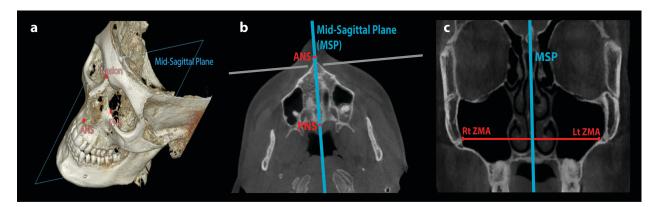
(a) CBCT image showing Mid-Sagittal Plane (MSP) on an initial CBCT using OnDemand (Cybermed, Korea). ANS, PNS and Nasion can be viewed as separate skeletal landmarks on the MSP. (b) Axial slice at pre-expansion with vertical line passing through ANS and PNS. (c) Coronal view of pre-expansion CBCT displaying measurements from the MSP to both the right and left ZMA. Right and left ZMA landmarks indicated in red at the most medial-superior location of the zygomatic-maxillary suture.
